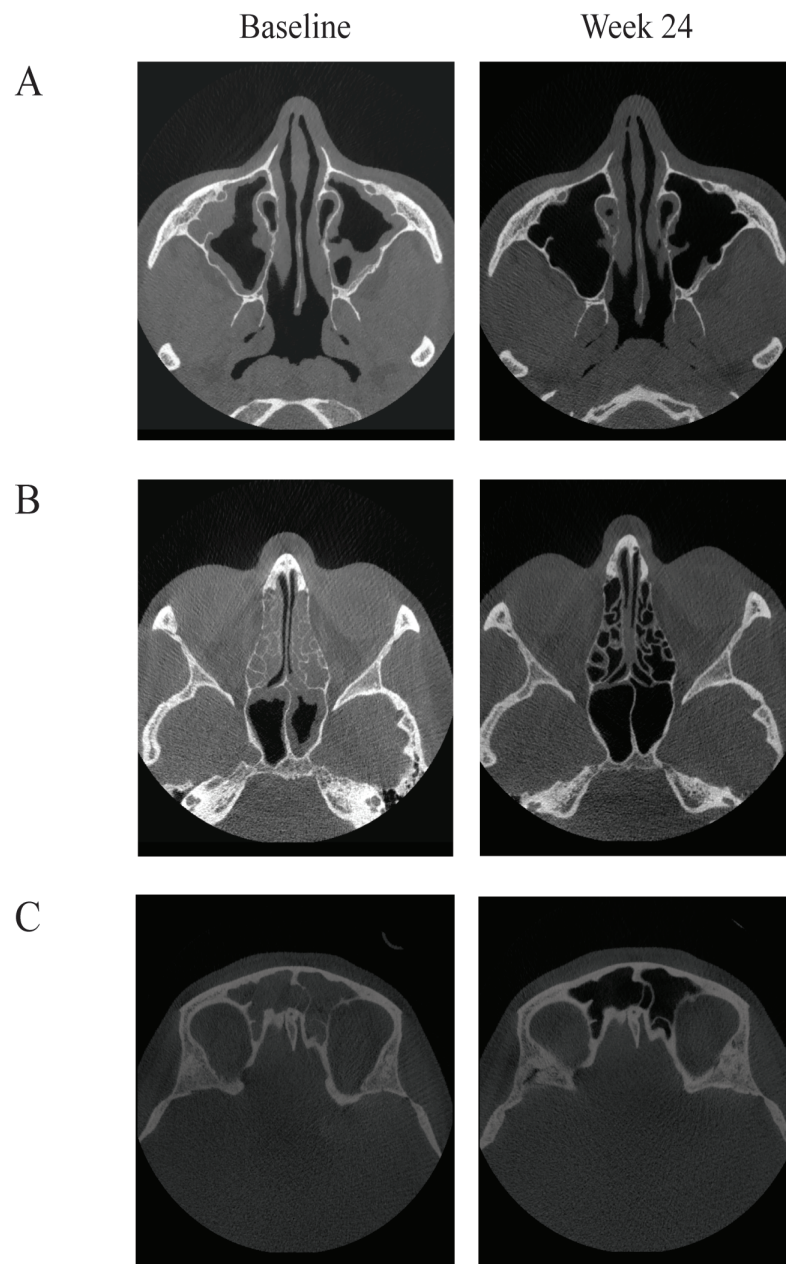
Baseline and week 24 sinus CT scans of a patient with sBEC ≥ 300 cells/ μ L treated with dupilumab, showing near complete resolution of opacification in (A) the bilateral maxillary sinuses, (B) the bilateral ethmoid and sphenoid sinuses, and (C) the bilateral frontal sinuses. CT, computed tomography; sBEC, screening blood eosinophil count.
